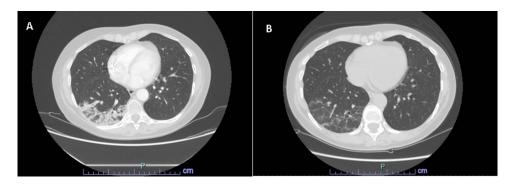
Clinical case of G2 Trastuzumab deruxtacan (T-Dxd)-induced pneumonitis after 39 cycles. This patient was treated with the T-Dxd for a refractory HER2+ metastatic (liver and skin) breast cancer. The patient was symptomatic with mild. Clinical examination showed fine crackles on auscultation at the right basal lung. The CT scan performed showed ground-glass area and parenchymal consolidation at the right basal pyramid with no concomitant pleural effusion (A). The patient promptly started oral steroids with rapid clinical improvement. A bronchoalveolar lavage was done and showed lymphocytic and giant cells infiltrates. The chest HRCT scan performed after one month confirm initial radiological improvement (B).
